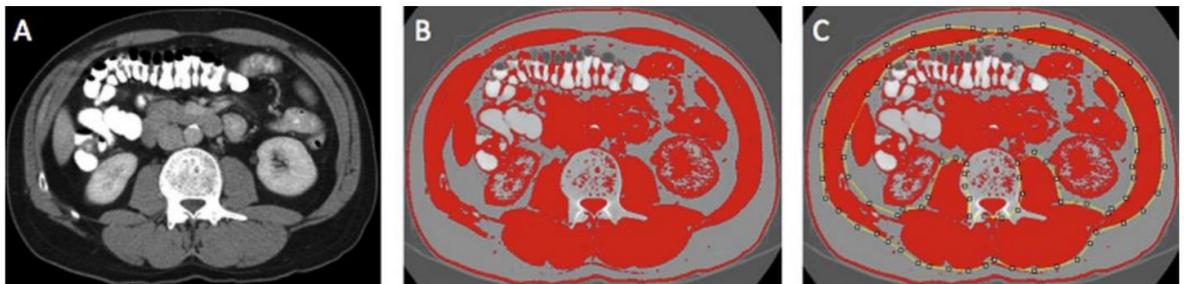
The use of ImageJ for analysis of skeletal muscle area/density (A) Axial CT slice at L3 level in portal venous phase, (B) Threshold selection of skeletal muscle, (C) Region of interest selection for skeletal muscle mass/density
